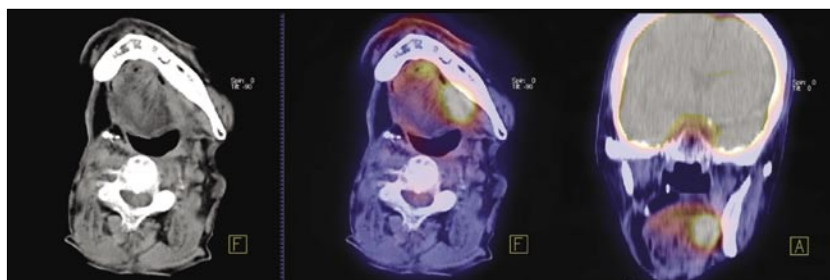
PET/SPECT of a 53-year-old male with a right tonsillar fossa squamous cell carcinoma. PET/CT images show a focal increased activity internal to the midline of the mandible suspicious for a second focus of malignancy (courtesy of Dr. Conti).
